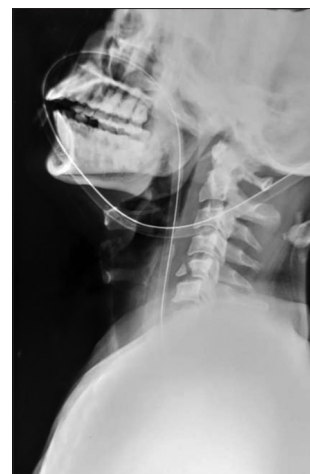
Plain radiograph lateral view demonstrating C5 vertebral body fracture flexion tear-drop type
